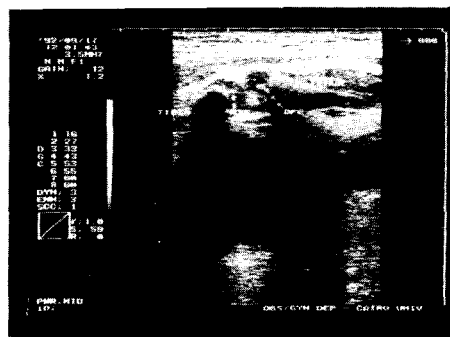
Longitudinal real-time sonogram of the fetal knee demonstrating the acogenic DFE and PTE.
